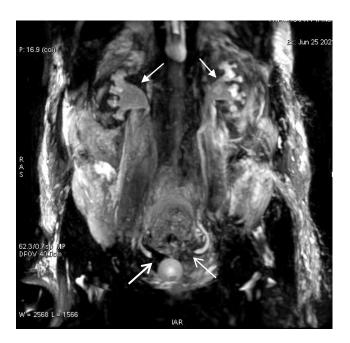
MRI: Both ureters have funnel-shaped narrowing in the prevesical segment (down arrows). Dilatation of the ureters with grade 2 to grade 3 hydronephrosis bilaterally (upper arrows).
